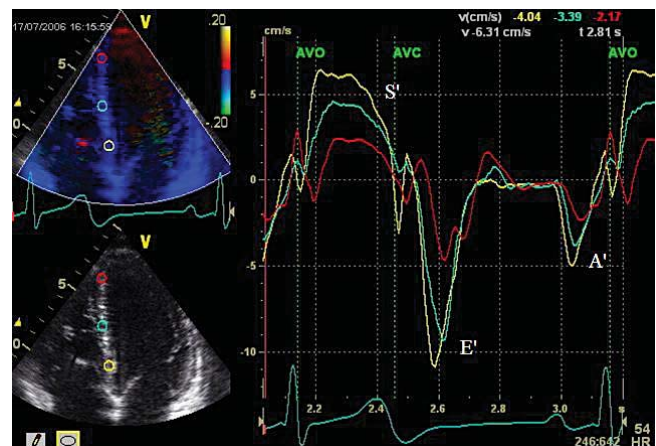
Colour tissue Doppler imaging with the offline curves obtained demonstrating the systolic S' and diastolic E' and A' velocities.
